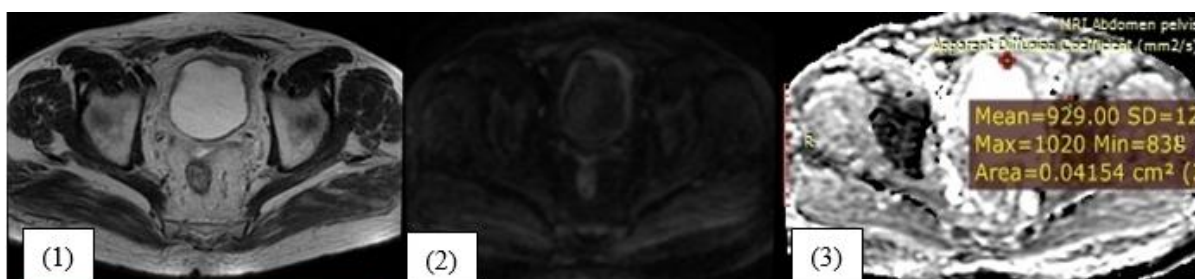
and 3) Male patient aged 56 years old diagnosed with Transitional cell carcinoma, staged T1, low grade (G1) (1) Axial T2-weighted images, shows polypoidal soft tissue mass lesion is seen involving the left anterolateral wall of the urinary bladder measuring about 1 cm in maximum diameter. The mass with intermediate SI infiltrating the hypo intense line of muscle layer at base of the mass denoting (Stage T2). (2)DW images, shows soft tissue mass lesion showed evidence of restricted diffusion evident by high signal intensity in the diffusion weighted images and urinary bladder walls are seen clearly identified with no disruption denoting stage (T1). (3)ADC value, was $0.93 \times 10^{-3} \text{ mm}^2/\text{s}$ denoting low grade (G1) tumor.
